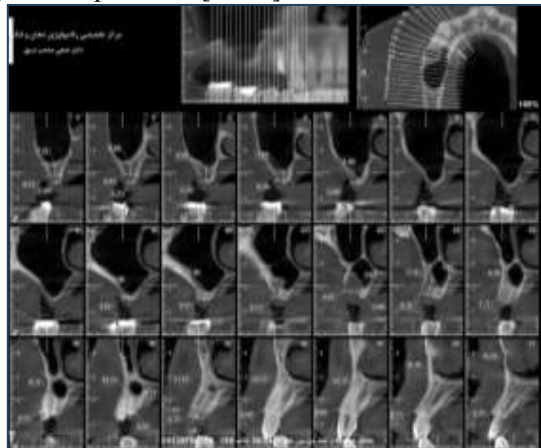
A panoramic image and the CBCT scan showing inadequate bone for direct implant placement in the posterior maxilla. The sinus lift surgery is necessary prior to the implant placement.
